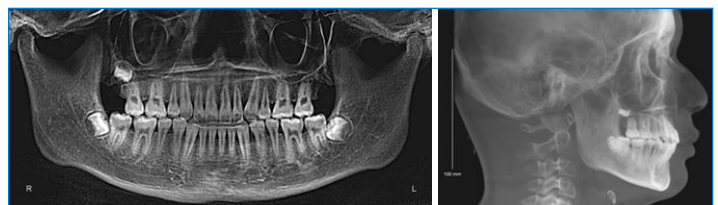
Posttreatment panoramic radiograph (left) and lateral cephalogram (right) (B.N., 14 years, 6 months)
